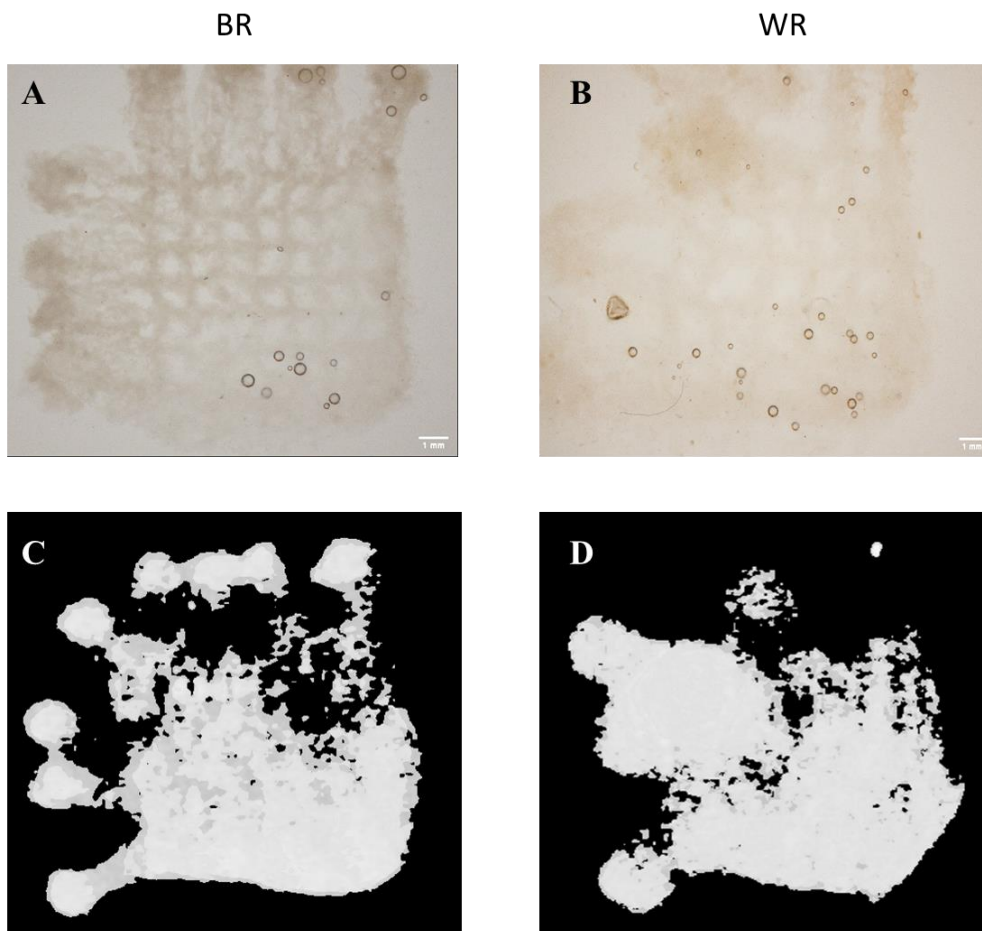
Printed Scaffolds and μ CT analysis. A- BR scaffold. B- WR scaffold. C- BR scaffold imaged through μ CT analysis. D- WR scaffold imaged through μ CT analysis. All images were taken after 14 days under x10 PBS (mineralization solution). Grey and white color represent unmineralized and mineralized spots, respectively.
